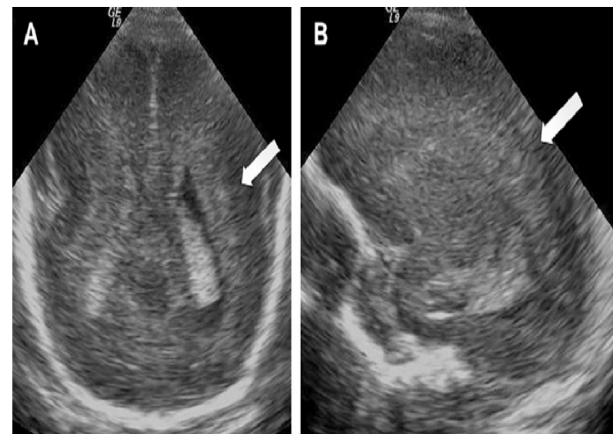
A: Neurosonogram showing periventricular leukomalacia. Fig. 1 B: Neurosonogram in which ventricles are visualized.
